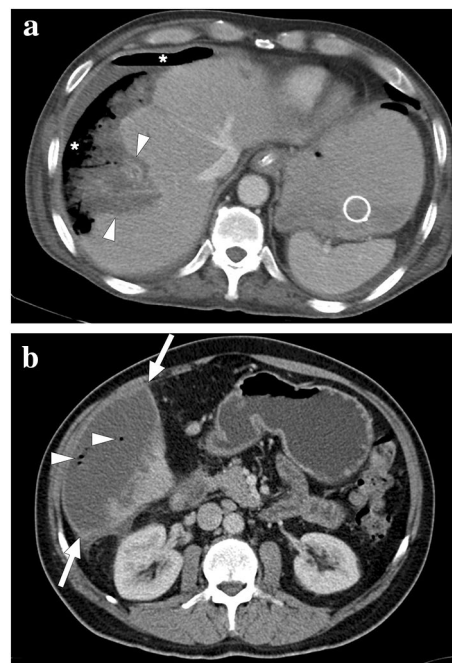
Two different patients with complicated liver infarcts. a A 65-year-old male patient with pancreatic adenocarcinoma underwent a Whipple operation. Three weeks after the operation, the patient presented with severe hematemesis. CT angiography revealed a gastroduodenal artery pseudoaneurysm as the underlying cause of upper gastrointestinal tract bleeding (not shown). An emergent catheter angiography and subsequent percutaneous embolization were performed. Ten days after the embolization, the patient again presented to ER with high fever, hypotension, and severe right upper quadrant pain. Axial plane postcontrast CT image showed necrotic liver parenchyma (arrowheads) with subcapsular and subdiaphragmatic air densities (asterisks). The constellation of imaging findings was found to represent the superinfection of the gangrenous liver segment. Emergent surgery was planned, but the patient expired 3 h after the CT scan. b A 57-year-old male patient underwent catheter angiography embolization of the giant liver hemangioma in segment 6. Twelve days after the embolization, the patient presented to the ER with a high fever, chills, and right upper quadrant pain. An emergent contrast-enhanced abdominal CT showed a large infarcted area in segment 6 (arrows) with air bubbles within this parenchymal segment (arrowheads). The imaging and clinical findings were considered to represent a superinfection of the infarcted parenchyma. Imaging-guided aspiration revealed purulent content and confirmed the diagnosis
